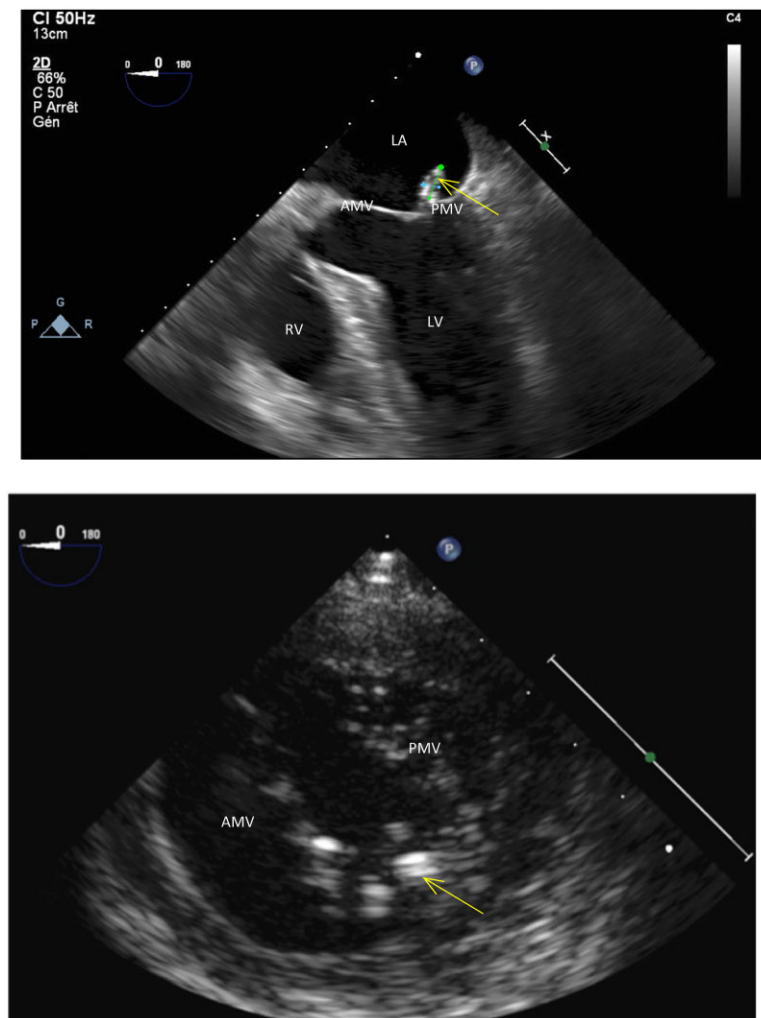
Transoesophageal echocardiography at J1: 8 mm vegetation on the anterior leaflet of the mitral valve in a zoom view at 0° (upper panel, vegetation indicated by the arrow) and in transgastric view (lower panel) showing the vegetation insertion point near the anterior commissure (indicated by the arrow). Anatomical landmarks: AMV, anterior mitral valve; LA, left atrium; LV, left ventricle; PMV, posterior mitral valve; RV, right ventricle.
